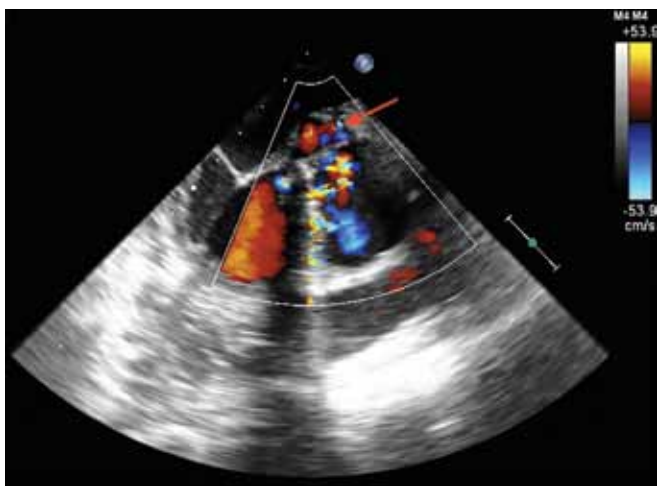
Transesophageal echocardiography, modified ME long axis with color flow Doppler (mid-systole). The LVOT pseudoaneurysm (red arrow) fills during systole as evidenced by color flow Doppler
